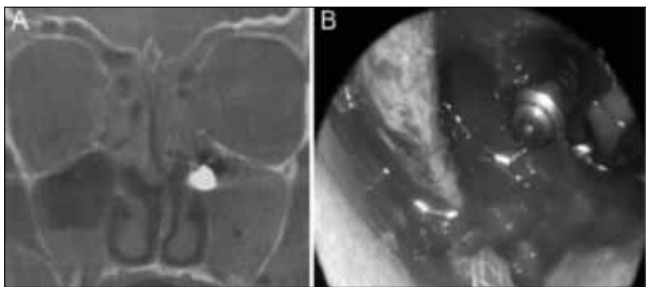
Patient 10. SCDDT resulting from implant dislocation (Class 2c). A) Coronal CT scan showing the implant inside the maxillary sinus, near the natural ostium but unable to be dragged in the ostiomeatal complex due to the small size of the natural ostium itself; B) Endoscopic endonasal surgery and implant removal.
